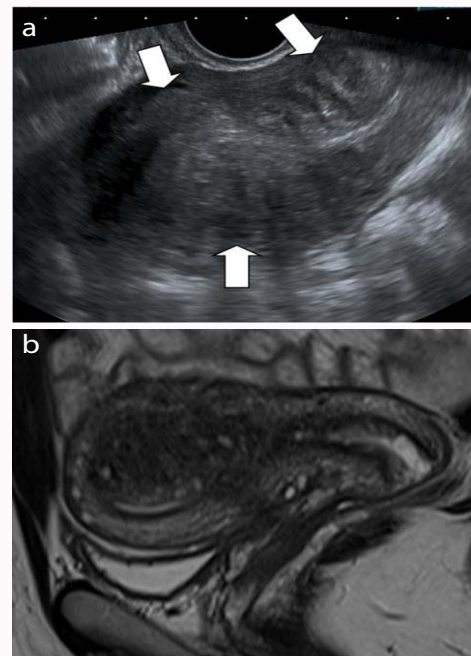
24 year-old woman who presented 9 week pregnant with vaginal bleeding and a hCG level at 872 749; subsequent pathology report from a dilatation and curettage material confirmed a complete molar pregnancy. Endovaginal ultrasound image in sagittal plane shows widely enlarged endometrial cavity with heterogeneous, mostly hyperechoic content and posterior delineation between endometrium and myometrium is lost (arrow).
